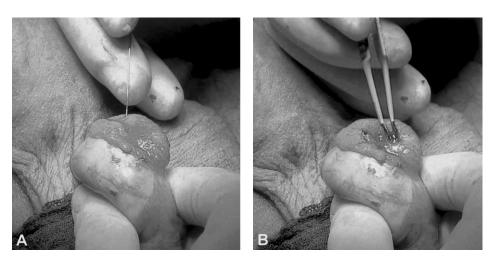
(a) Intraoperative measurements of intratesticular tissue perfusion with a 1-mm tip Laser Doppler Probe; (b) TESE biopsy after intratesticular perfusion measurement.
